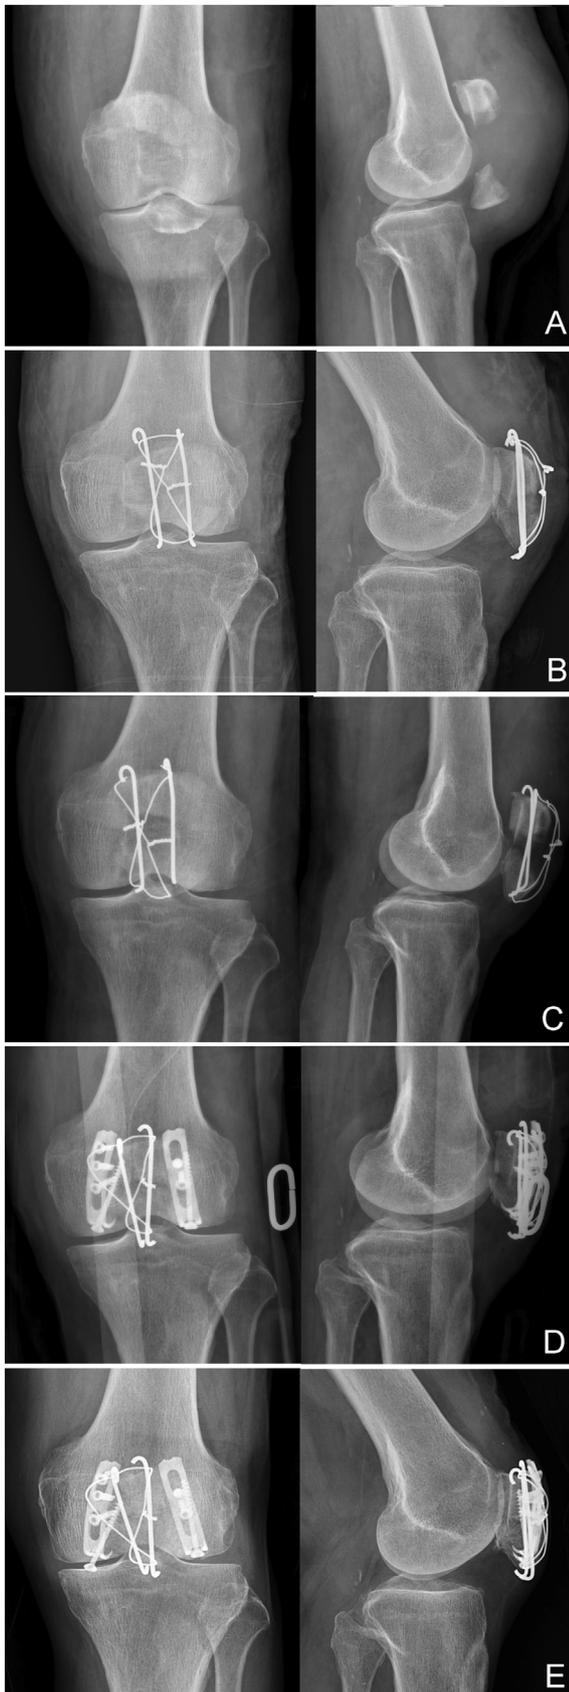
Eighty-four-year-old male patient. A. Initial radiography. B. Fixation with tension band wiring (TBW). C. Reduction loss at postoperative 4 weeks. D. Revision with TBW augmented with hook plates. E. Three-year postoperative radiograph.
